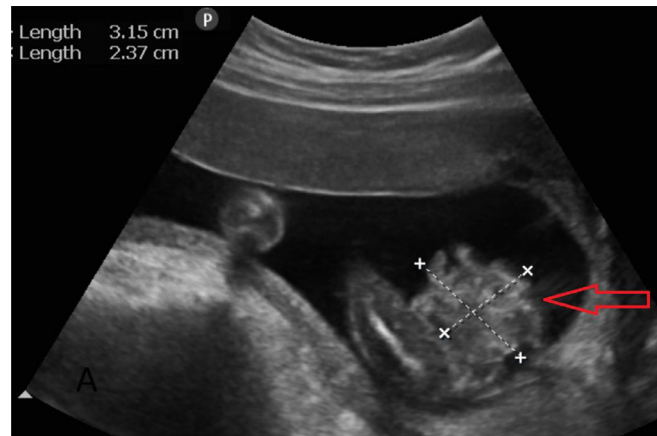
Greyscale B mode ultrasound image in sagittal oblique section of antenatal anomaly scan revealed herniated bowel loops (red arrow) measuring 3.1 × 2.3 cm through an abdominal defect.
